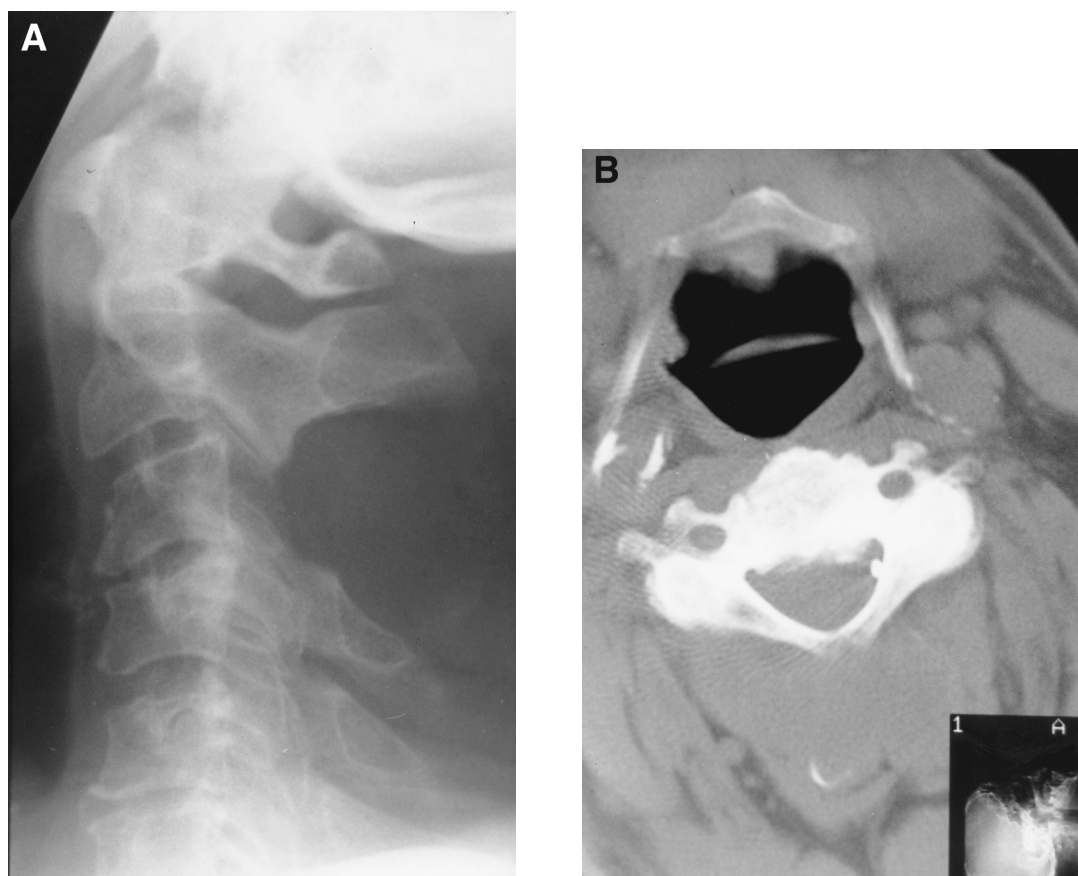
Spinal metastasis involving posterior elements, as shown by (A) plain film and (B) CT scan.
